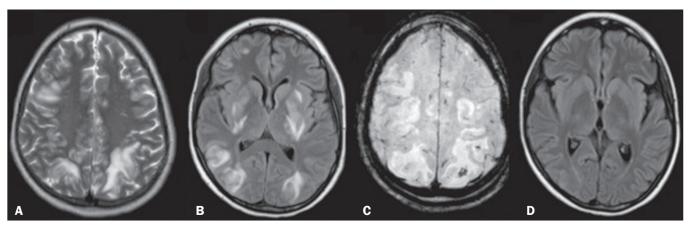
MRI scan of the skull of a female patient diagnosed with systemic lupus erythematosus who developed reversible posterior encephalopathy. A,B: Axial T2-weighted and FLAIR images, respectively, showing bilateral cortical-subcortical areas of hyperintense signals in the occipital, parietal, and frontal lobes, with a slight expansile effect, including the basal ganglia. C: Susceptibility-weighted imaging sequence identifying a subcortical focus with a hypointense signal in the left parietal lobe (petechial hemorrhage). D: Follow-up image obtained after the acute stage, showing reduction of the previously demonstrated lesions.
